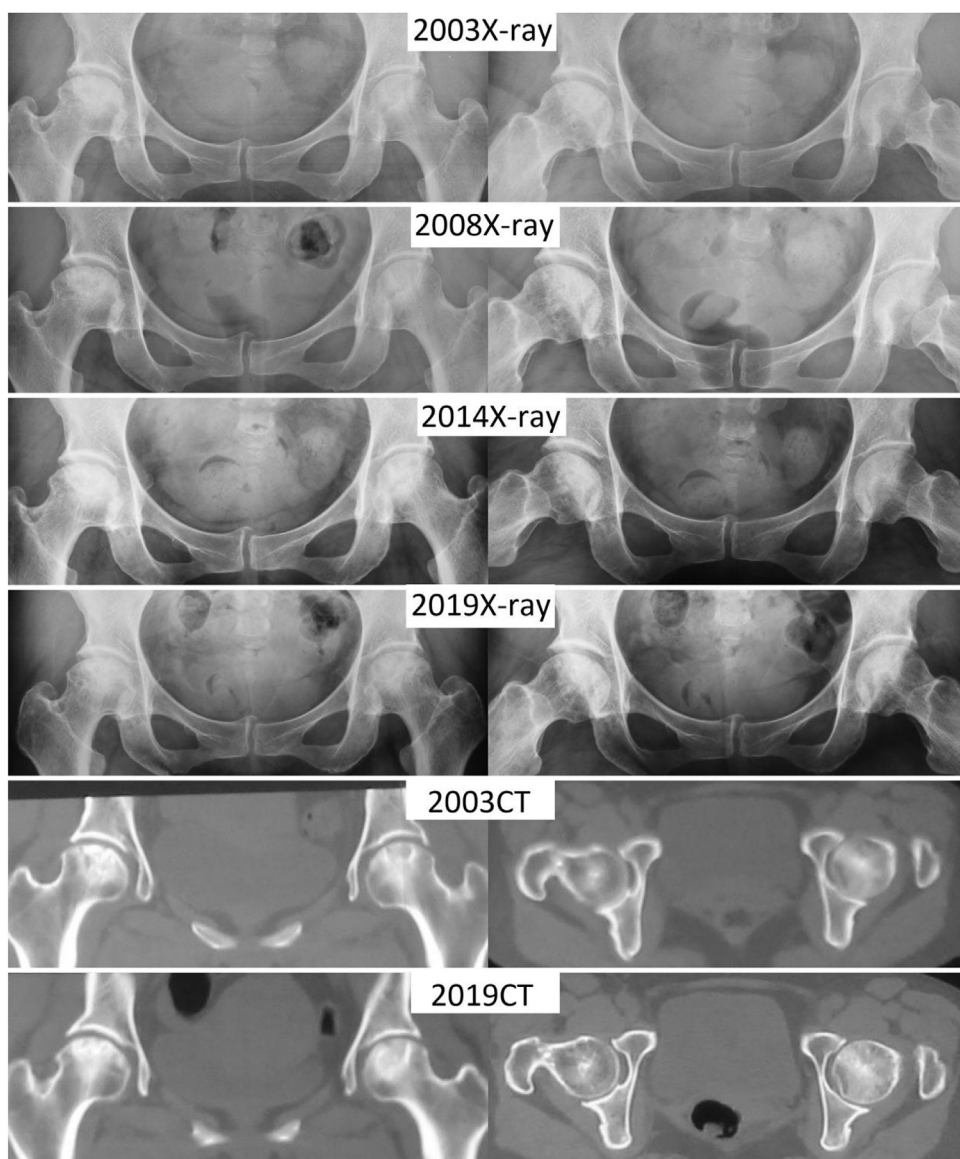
Medical imaging series from a 35-year-old female (patient number SARS03017) with ONFH received HGF therapy in 2003. Plain radiographs in 2003 suggested bilateral ONFH (left: ARCO Stage III and JIC Type C1, right: ARCO Stage III and JIC Type C1). Plain radiographs series (from 2008 to 2019) showed the development of sclerosis in the necrotic lesions and osteoarthritis in the hip joints. CT images in 2019 confirmed the presence of osteoarthritis (left: K-L Grade 1, right: K-L Grade 2) without severe depression of femoral head. ARCO = Association Research Circulation Osseous; CT = computed tomography; HGF = Huo-Gu formula; ONFH = osteonecrosis of the femoral head.
